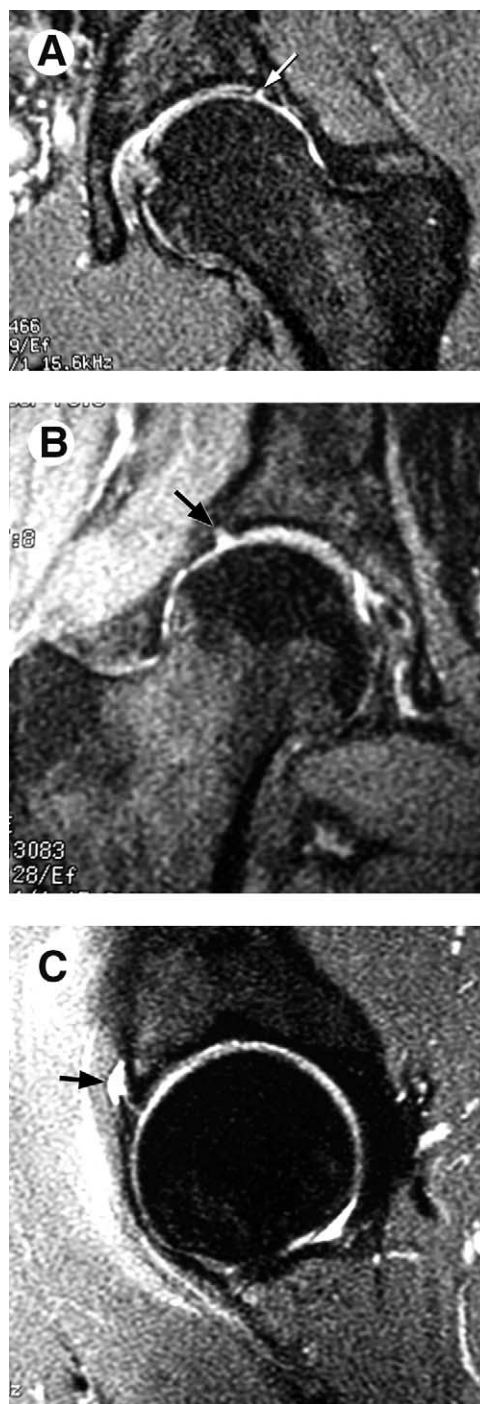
Three National Hockey League hockey players were referred, each with a 2-week history of hip pain after an injury on the ice. Each case showed MRI evidence of labral pathology (arrows). These cases were treated with 2 weeks of rest followed by a 2-week period of gradually resuming activities. Each of these athletes was able to return to competition and have continued to play for several seasons without needing surgery. (A) Coronal image of a left hip shows a lateral labral tear (arrow). (B) Coronal image of a right hip shows a lateral labral tear (arrow). (C) Sagittal image of a left hip shows an anterior labral tear with associated paralabral cyst (arrow). (Figure © J.W. Thomas Byrd.)
